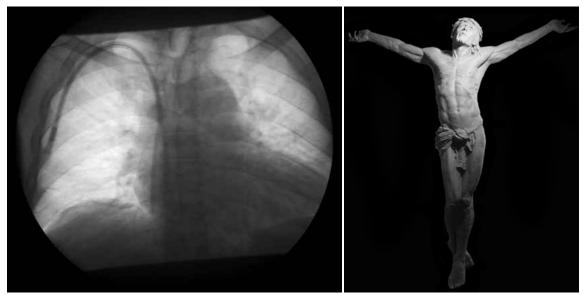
Christ sculpture (used with permission) and Zen's x-ray
